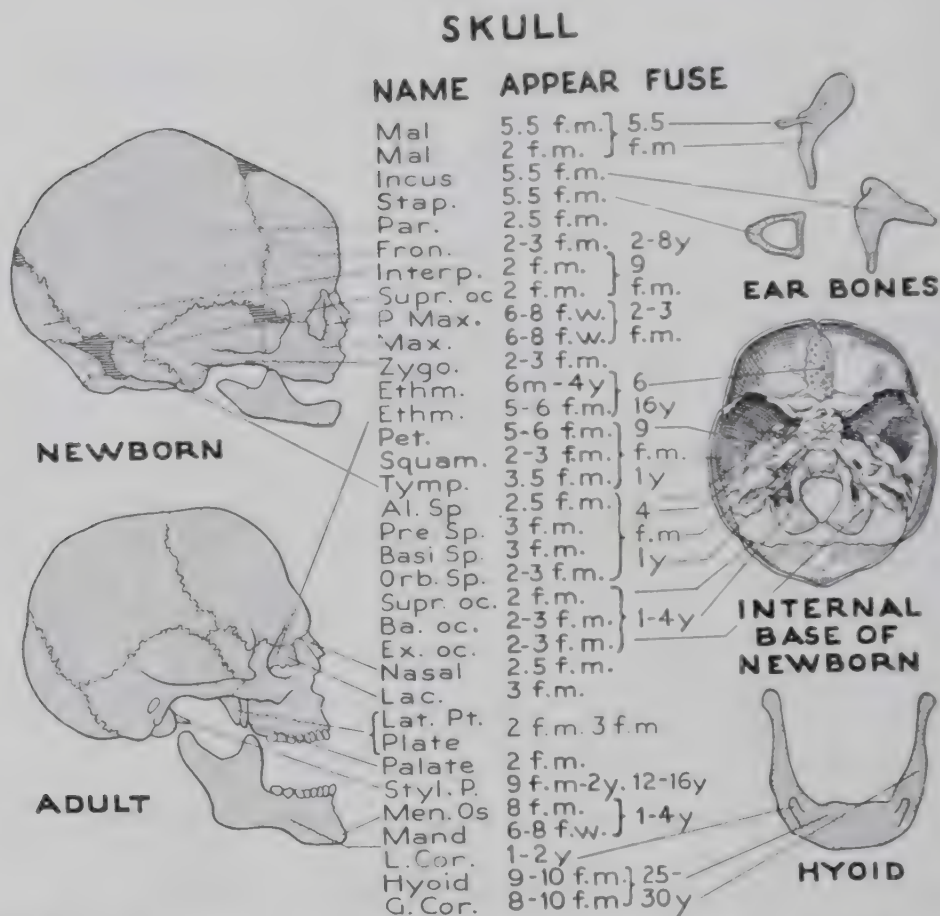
Fetal and postnatal ossification of the skull, showing the time of appearance and of fusion of the different ossification centers: *f.m.*, fetal month; *f.w.*, fetal week; *y*, year. Reprinted from Scammon in Morris' Human Anatomy. (From Caffey, J.: Pediatric X-Ray Diagnosis, Year Book Publishers, Inc.)
